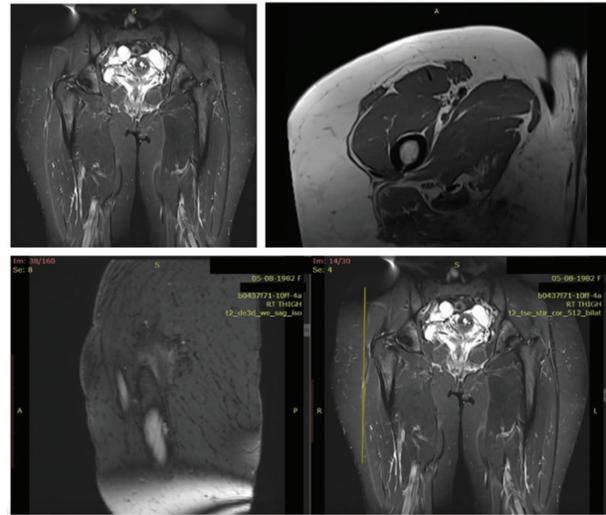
MRI images of the patient suggestive of right ITB thickening and greater trochanteric bursitis with tiny cyst formation suggestive of likely ganglion cyst formation. ITB, iliotibial band; MRI, magnetic resonance imaging.
